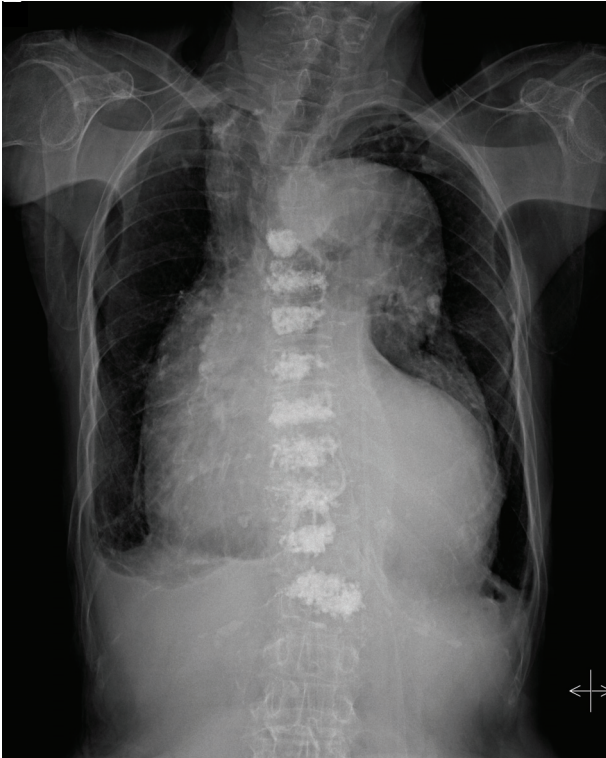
The posteroanterior chest radiograph showed an enlarged, tortuous aorta.
